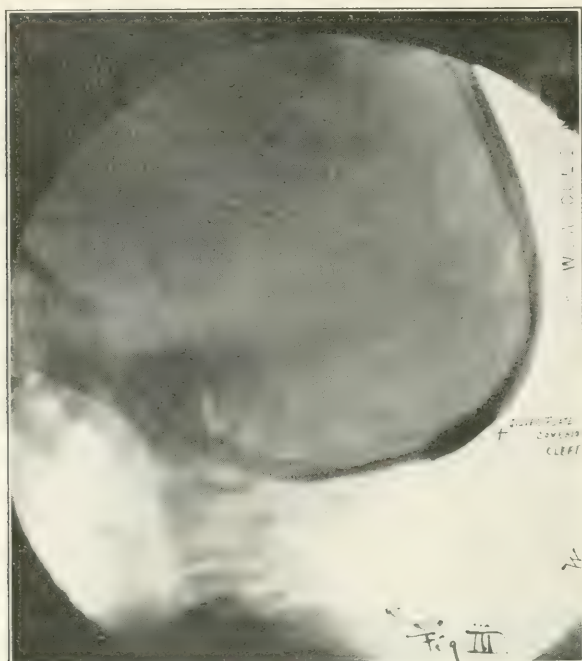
Radiograph of skull in Case I, after operation, showing position of silver plate over cleft.
